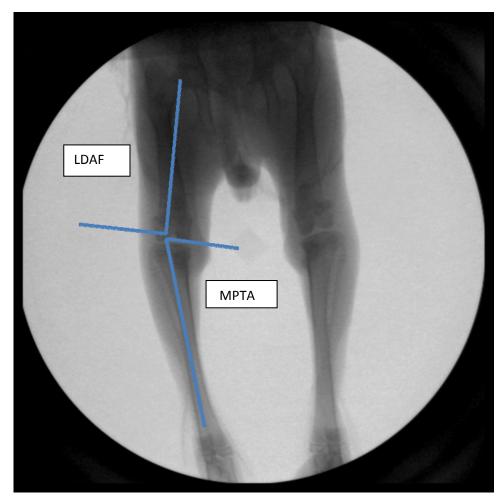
Angle measurement from radiographic images.
